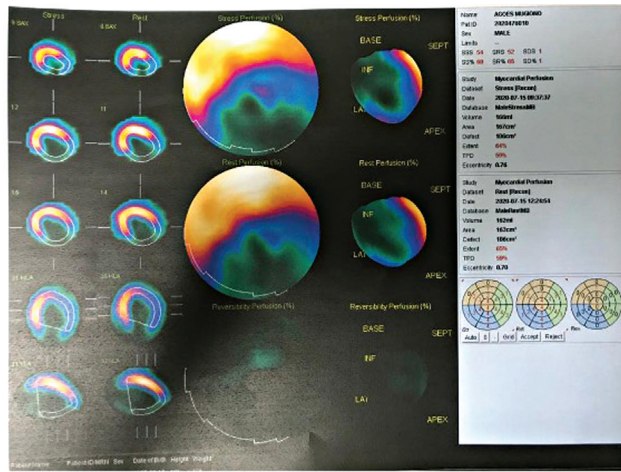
MPI-SPECT. MPI-SPECT, myocardial perfusion imaging by single-photon emission tomography.
